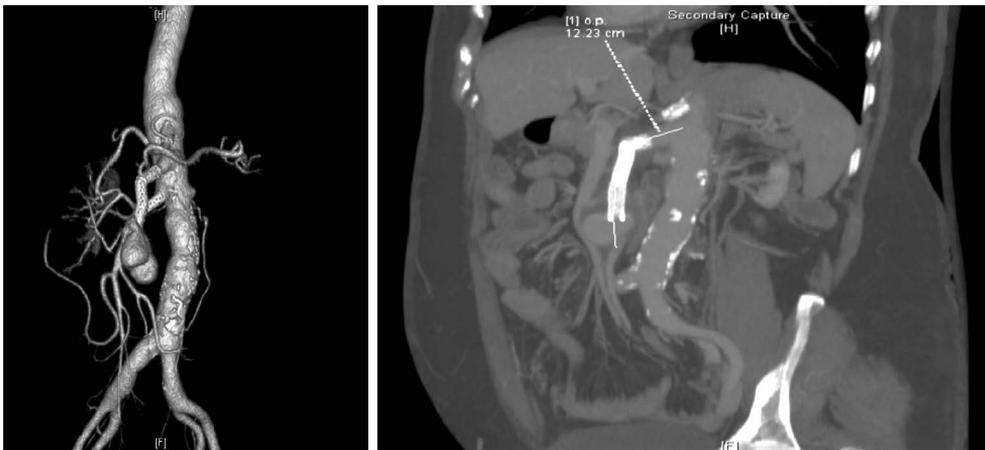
Abdominal computed tomography and three-dimensional reconstruction showing distal a superior mesenteric artery pseudoaneurysm with a superior mesenteric artery stent *in situ*.
